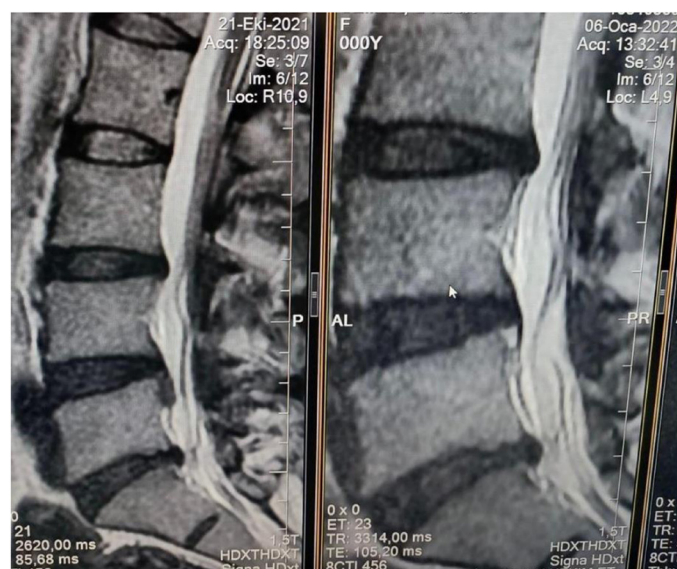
Sagittal lumbar MRI images of a 30-year-old female patient at the L4 - L5 level. (A) Pre- injection: sequestered disc herniation causing compression. (B) Three months post- injection: marked regression of the sequestered fragment and decompression of neural structures
